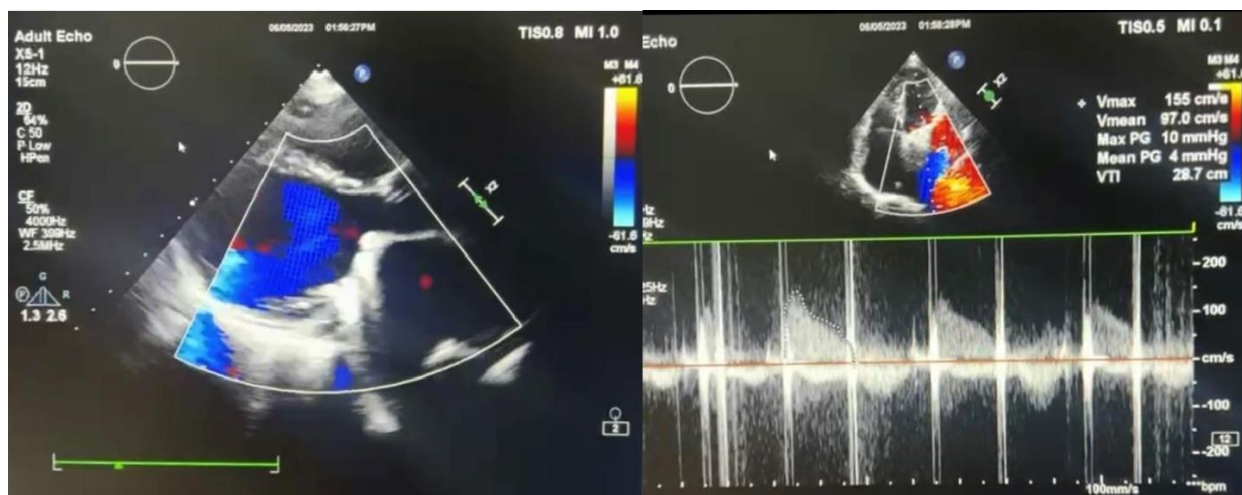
(b): Color Doppler Study at the level of Medtronic Hall tilting disc mitral prosthesis: multiple peripheral diastolic flow jets are seen.
